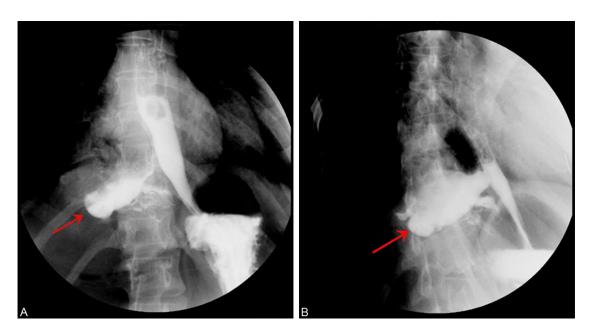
The esophageal iodine radiography showed that the iodine overflew in the lower esophagus and irregular lamellar high-density shadow within filling defect, there was no thickening and disruption of esophageal mucosa.
